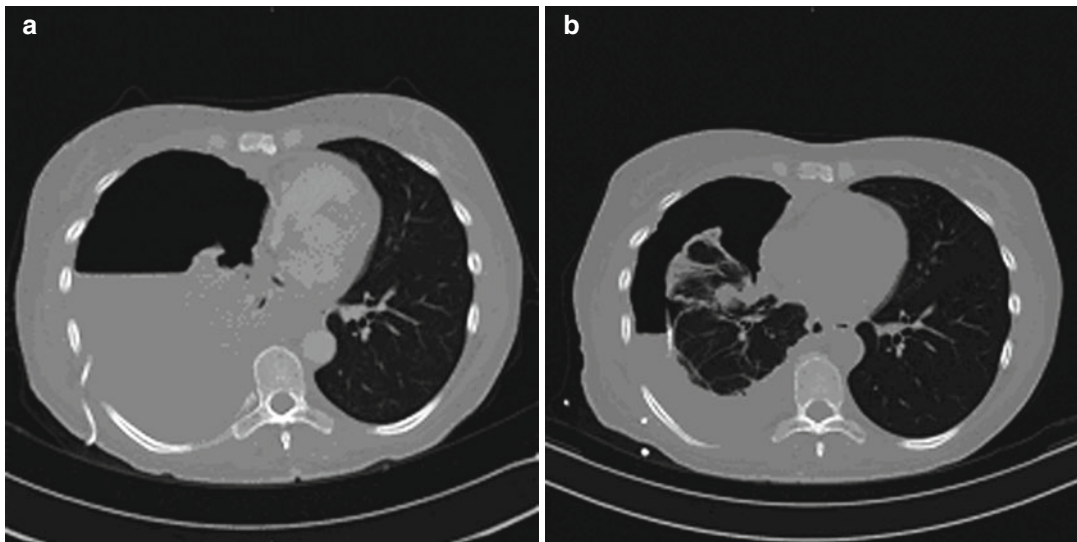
CT of the chest during the course of IL-2/LAK immunotherapy of malignant pleural effusion. Patient Sh. Lung cancer (the right lung), right-sided pleuritis. (a)
